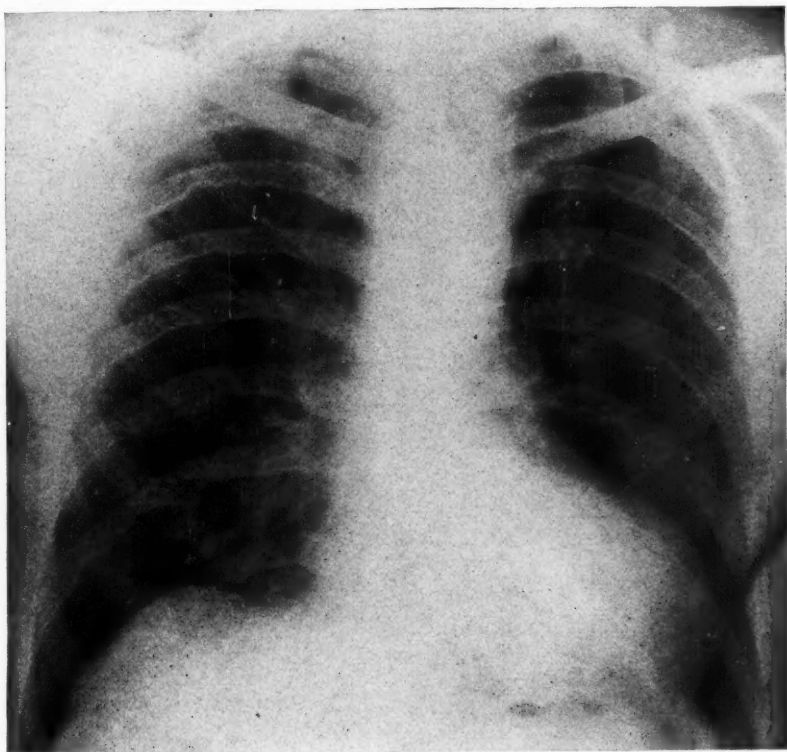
Roentgenogram of chest of case of coarctation of aorta. Heart enlarged to left, supracardiac shadow normal, erosion of lower borders of ribs, right 4-9 and left 5-8, inclusive.
